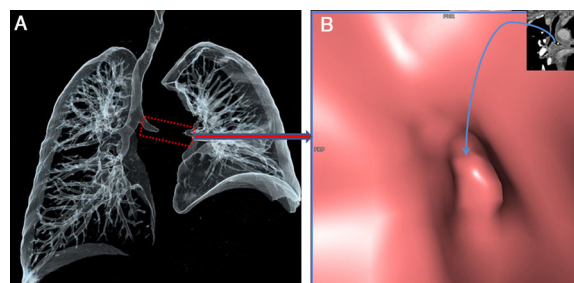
Three-dimensional volume-rendered air-specific coronal plan MDCT image (A) and virtual CT bronchoscopy (B) demonstrate obstruction (frame and arrow) of the left main bronchus.
